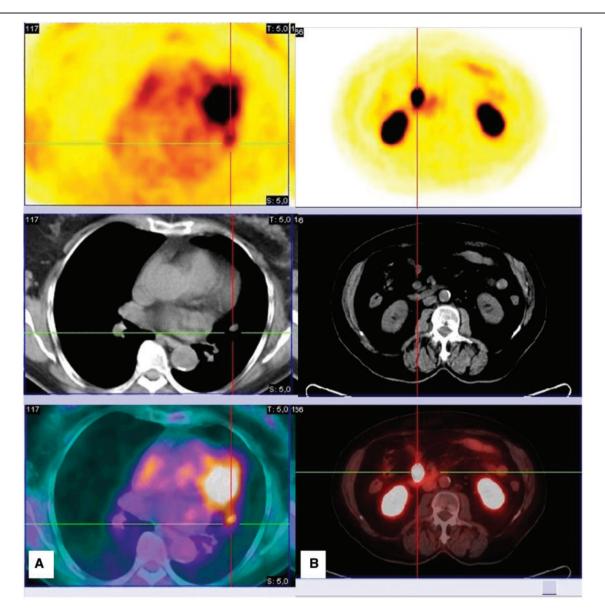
(A) [¹⁸F]FDG PET/CT located a tumor with low glucose uptake in the lingula. (B) [⁶⁸Ga]SSTR-PET/CT detected somatostatin receptor positive lesions in the terminal ileum and peripancreatically.
